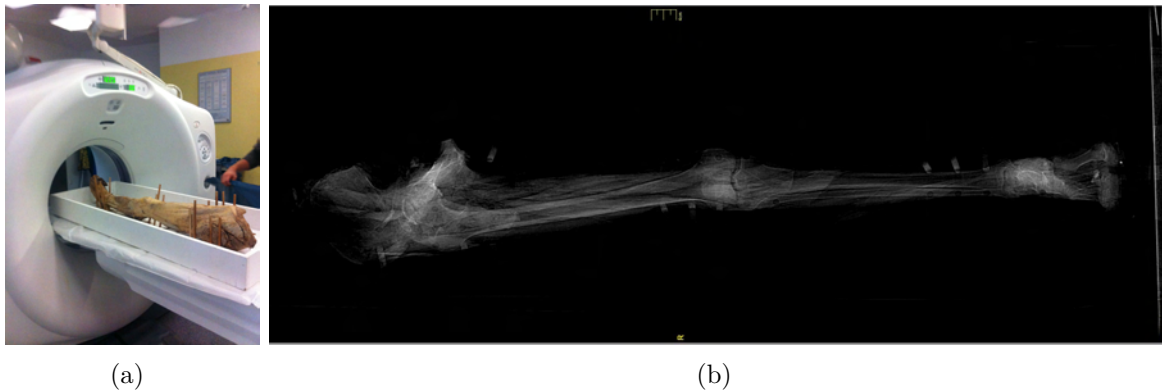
(a) A CT scanner (Siemens SOMATOM Sensation 64-slice configuration) used for taking the CT image of a human corpus leg; (b) A CT image slice of the human corpus leg on the frontal plane .
